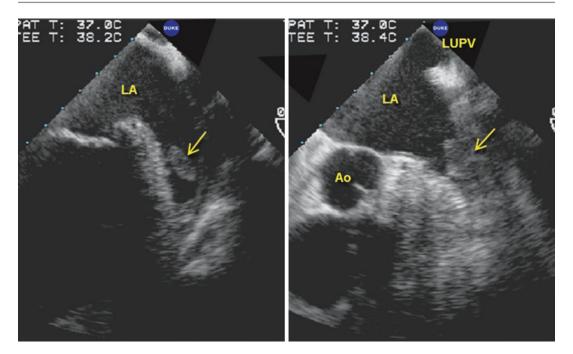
Transesophageal echo views of a patient with atrial fibrillation. Slight alteration of the probe position demonstrated more of the thrombus (right panel)
